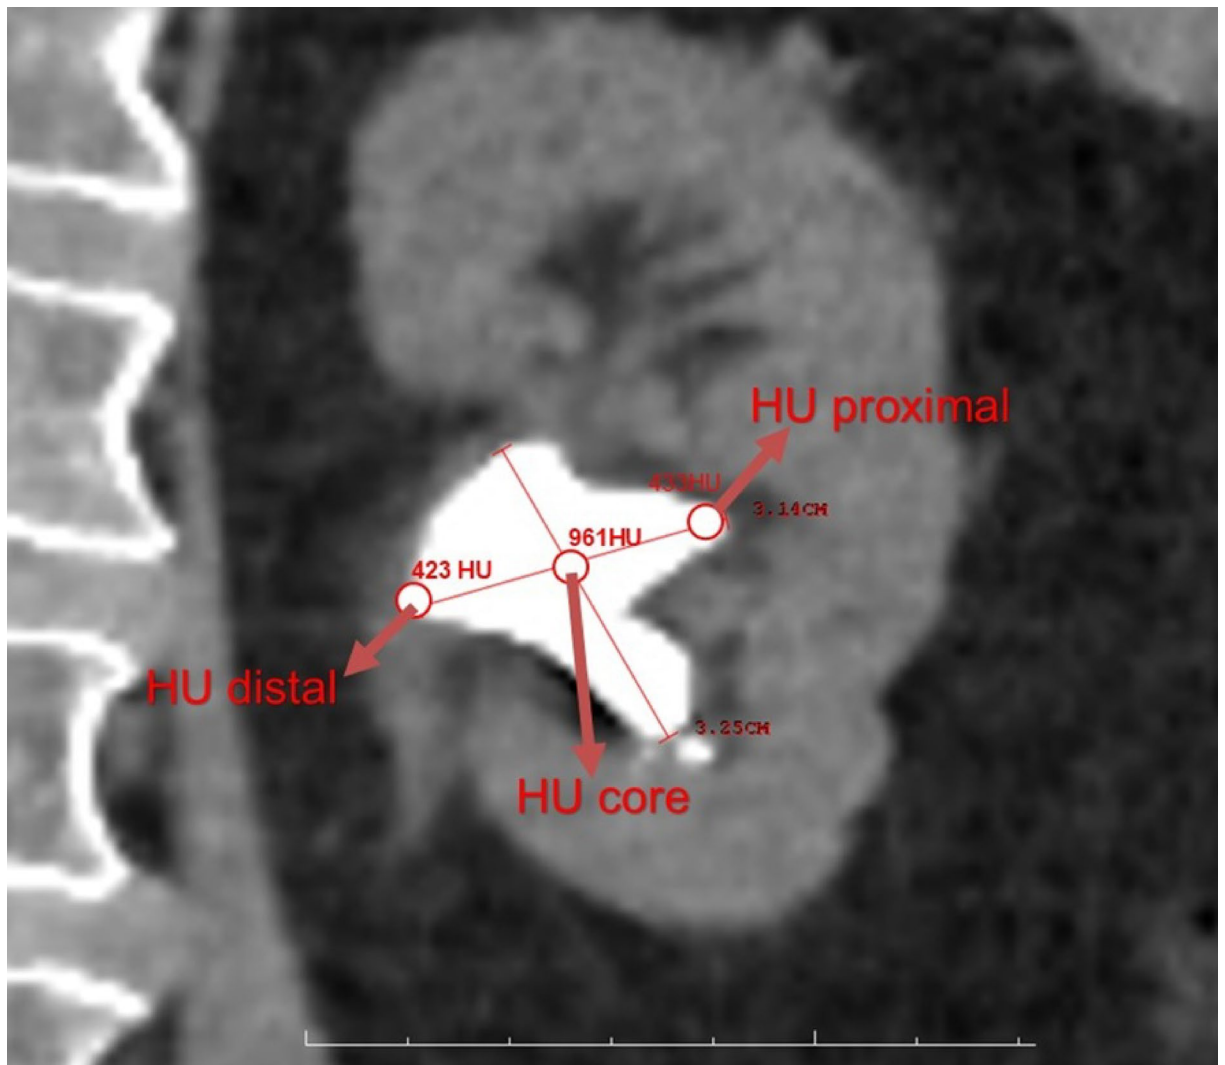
Hounsfield unit (HU) measurements taken at the core of the stone (HU_{core}), the proximal surface of the stone periphery ($HU_{proximal}$), and the distal surface of the stone periphery within the collecting system (HU_{distal}) on the non-contrast computed tomography image.
